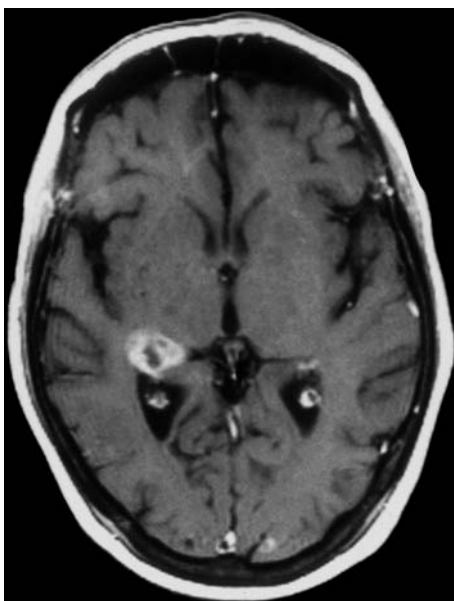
A 63-year-old woman with acute vision impairment and known breast carcinoma. Diagnosis: metastasis at the right lateral geniculate nucleus. MR: a Axial T1-weighted contrast-enhanced image showing a central necrotic tumor in the region of the right thalamic pulvinar. b Coronal T2-weighted view with infiltration of right optic tract (arrow) and the lateral geniculate nucleus. (With permission of Dr. R. Gustorf-Aeckerle, Katharinenhospital, Stuttgart)
